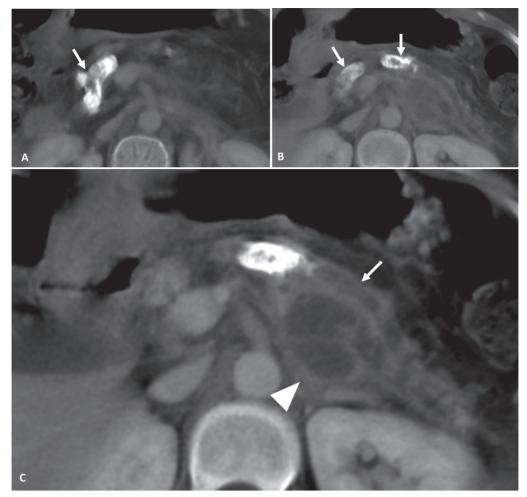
A 35-year-old male patient with tropical chronic pancreatitis (TCP) with a recurrent episode of acute pancreatitis. Axial contrast CT images show atrophic pancreas, dilated main pancreatic duct (C, arrow), large intraductal calculi in the head (A, arrow), body region (B, arrow) and pseudocyst in the body region of the pancreas (C, arrowhead).
